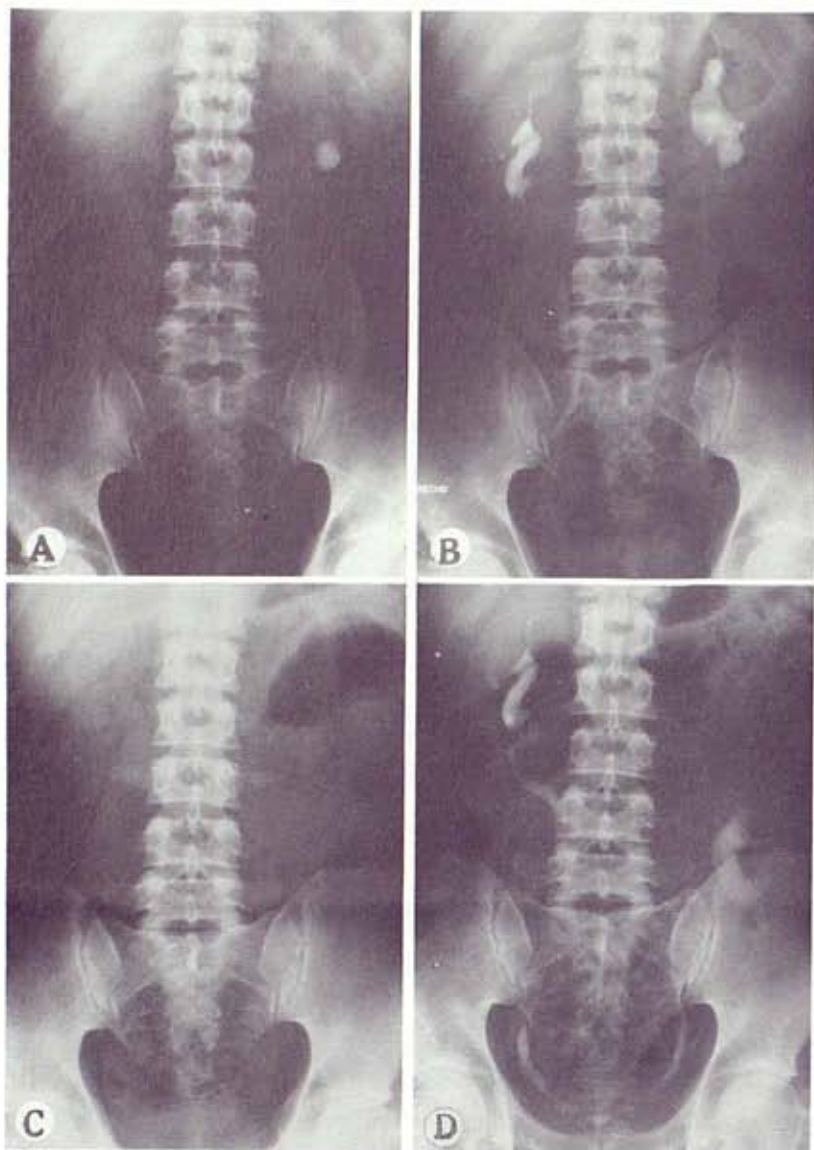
Case 3. *A*, x-ray reveals relapsing left renal lithiasis. *B*, preoperative IVP shows bilateral renal malrotation and discrete left pyelocaliceal ectasia. *C*, postoperative x-ray. *D*, postoperative IVP.
